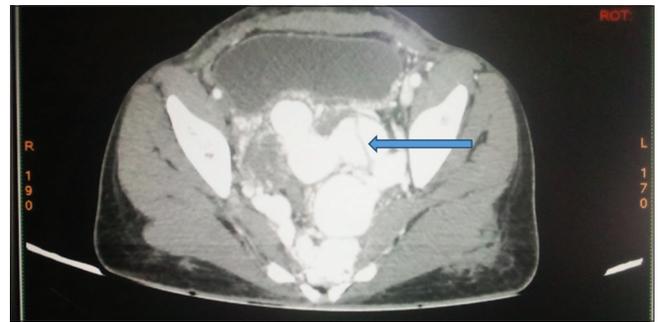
A computed tomographic angiogram axial view at the level of the pelvic cavity showing contrast opacified dilated and tortuous left iliac veins with a dividing linear septum appearing as a linear filling defect; left blue arrow
